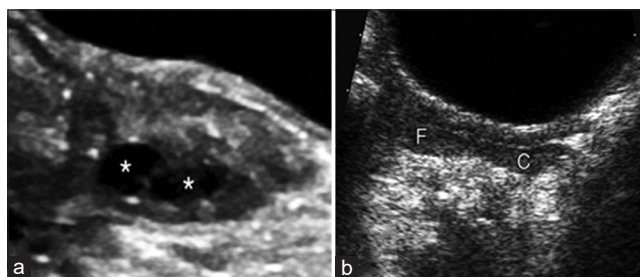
(a) Sagittal ultrasound of the ovaries in an 11-month-old infant showing normal follicles (*). (b) Sagittal ultrasound of the uterus in a 7-year-old girl shows a cervix (c) which is comparable in thickness to the fundus (f) [24]
